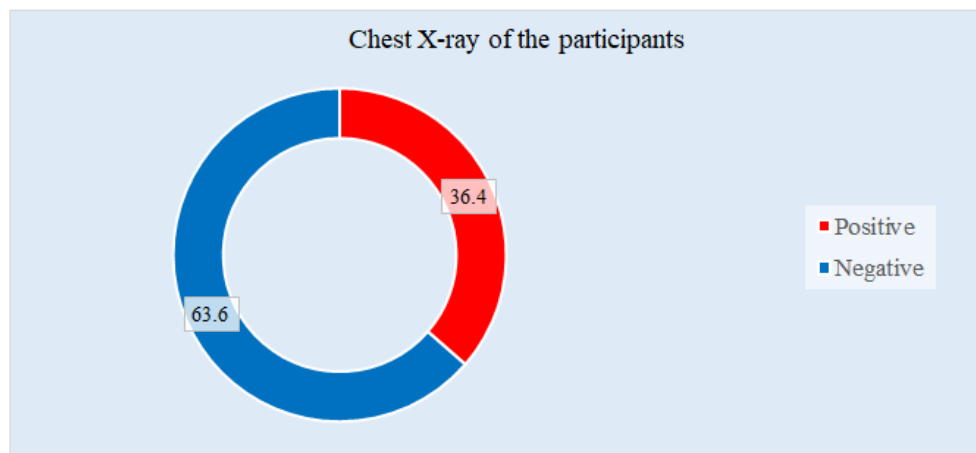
Ring chart showed distribution of the respondents by chest X-ray, (N=77)
